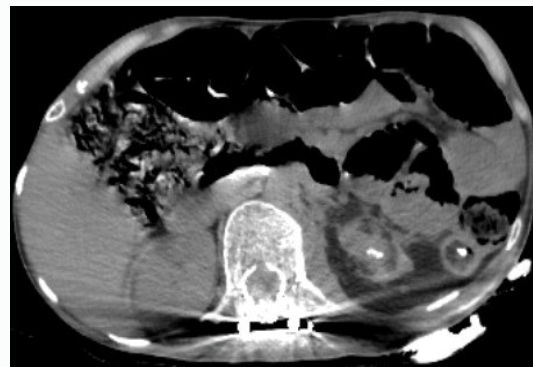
CT scan image showing presence of contrast and hence, communication between skin, left renal pelvis and left descending colon.
